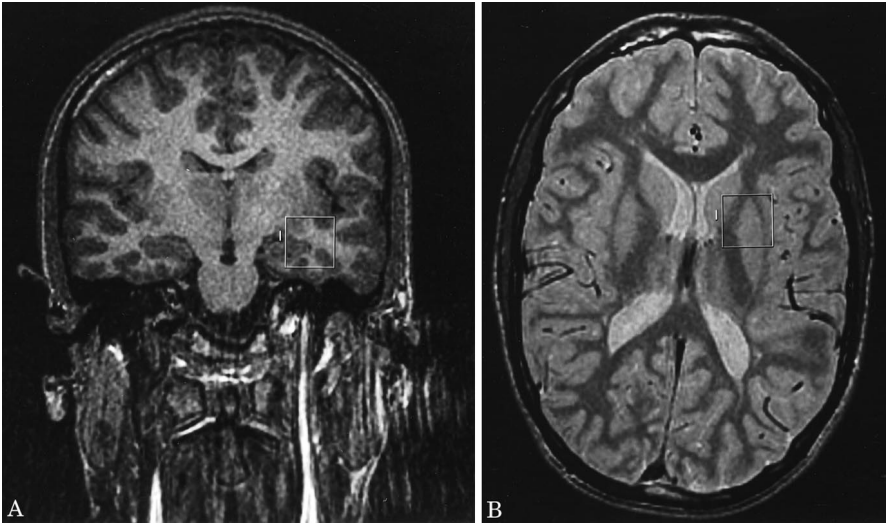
Coronal and axial ¹H-MR images show placement of the volume of interest in the left midtemporal region (A) and the left basal ganglia region (B).
